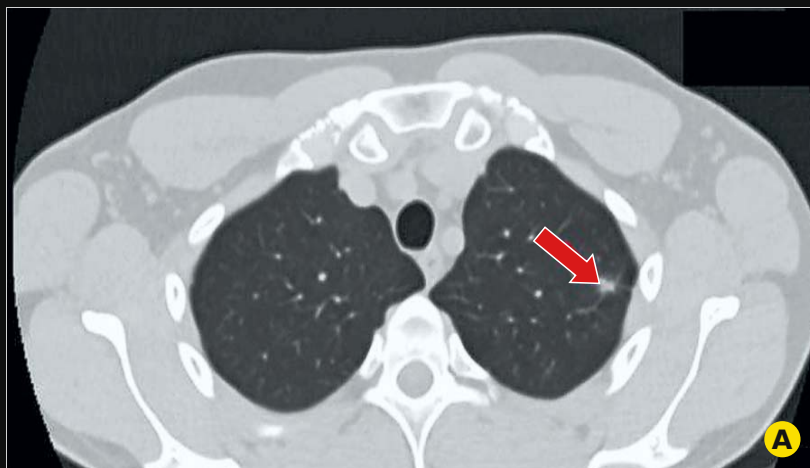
CT Scan - Axial aspects describing a pseudo-nodular, diffusely contoured, infiltrate of approximately 10 mm, located in the apical left upper lobe (LUL), interpreted as a possible sequelae
